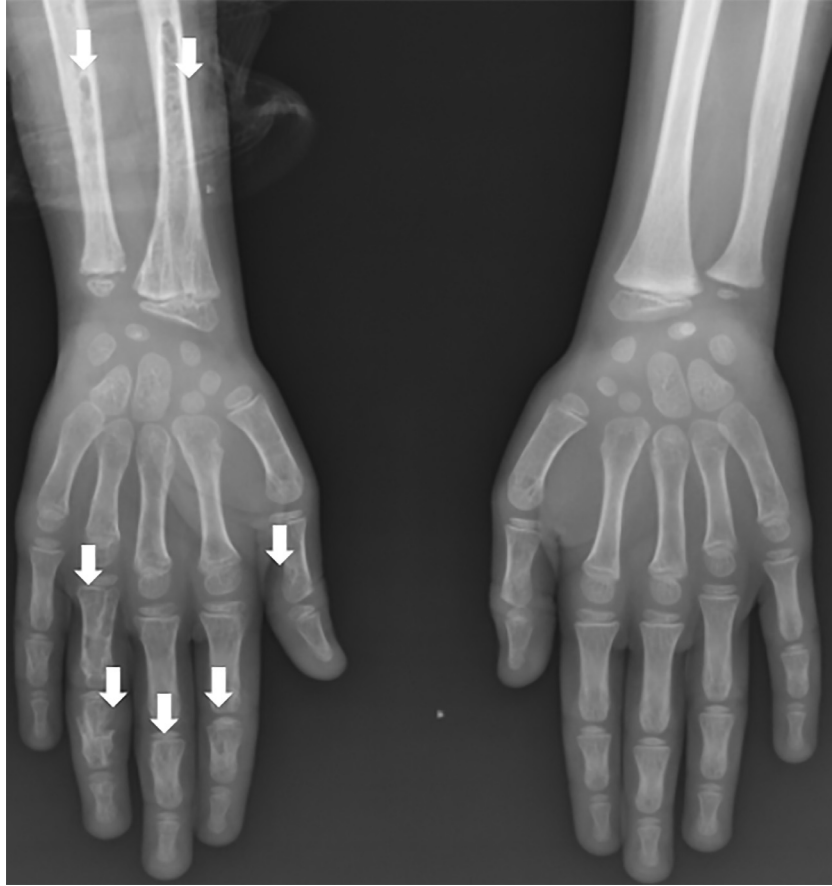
X-ray of the hands reveals bone demineralization of the right upper limb’s radial and ulnar diaphysis, as well as the presence of osteolytic lesions of the phalanges (white arrow).
